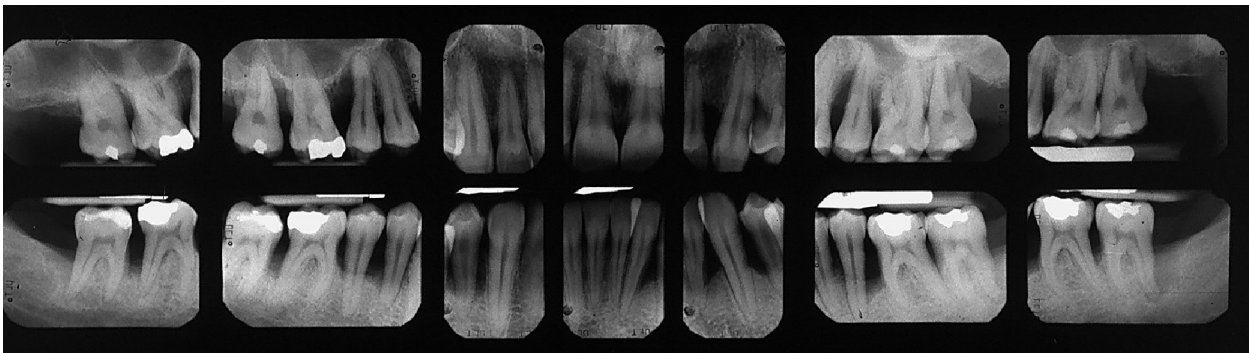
X-ray survey: 14 periapical radiographs
